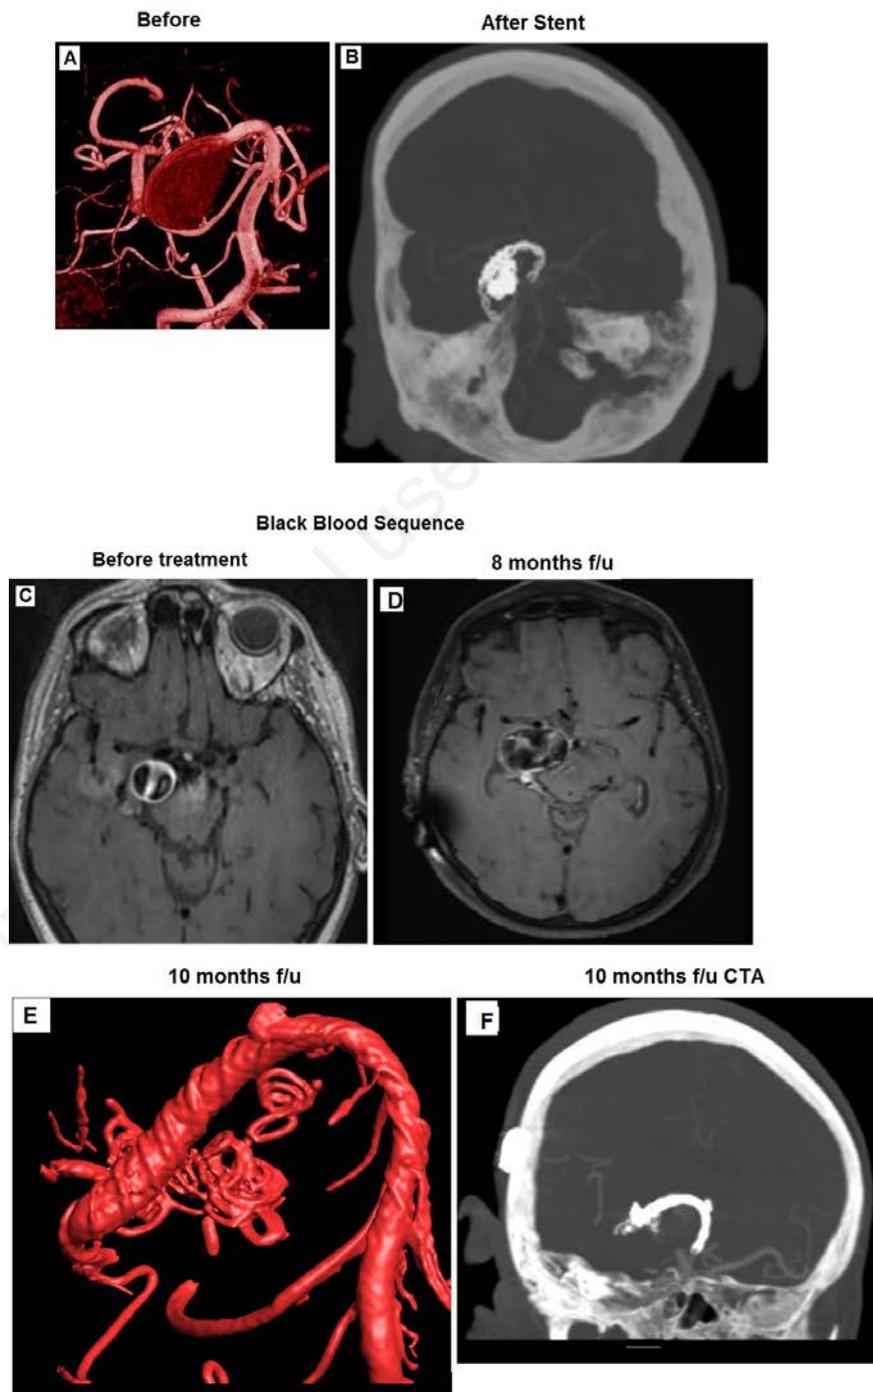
Posterior artery fusiform aneurysm in a 67 y.o. female: A) 3D reconstructed angiogram showing the fusiform posterior cerebral artery aneurysm in segments P1-P2; B) CTA after coiling and stenting; C) black blood MRI showing a perimetric contrast wall enhancement of the aneurysm before treatment; and D) after treatment; E) the 10 months follow up after the second stenting shown in 3d angiography reconstruction; F) CTA after the second stenting. No residual aneurysm is seen.
